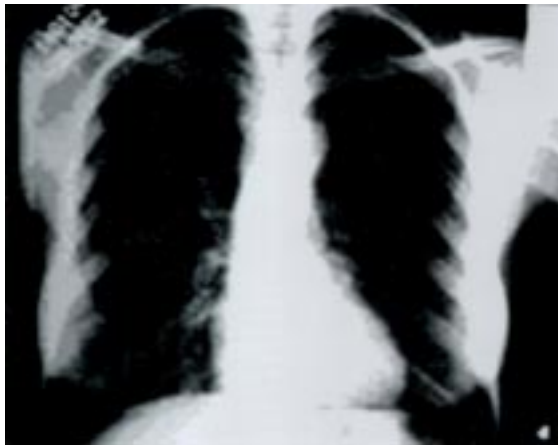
Chest radiograph (postero-anterior view) with no remarkable findings.
